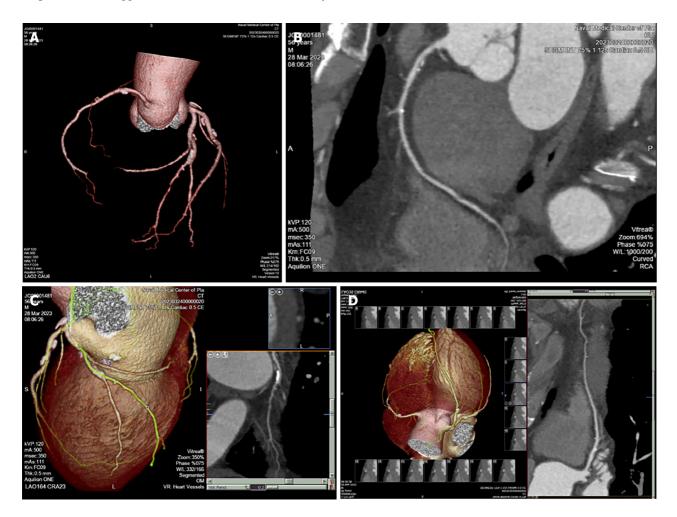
Transport pilot coronary computed tomographic angiography examination reveals coronary artery stenosis. A: All coronary artery images show mixed plaques with four vessel lesions and mild to moderate stenosis of the lumen; B: Right coronary artery, mixed plaques in the proximal segment, calcified plaques in the middle segment, soft plaques in the distal segment, and mild to moderate narrowing of the lumen; C: Obtuse marginal branch mixed plaques in the proximal and middle segments, with mild to moderate narrowing of the lumen; D: Left anterior descending of coronary artery, mixed plaques in the proximal and middle segments, with mild to moderate narrowing of the lumen; D: Left anterior descending of coronary artery, mixed plaques in the proximal and middle segments, with mild to moderate narrowing of the lumen.
